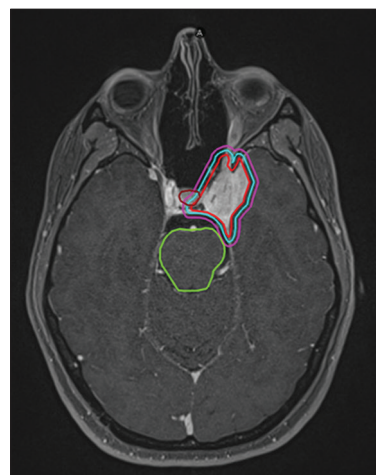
Pre-treatment magnetic resonance imaging (MRI). Colours only provide a visual representation of the cited area (pre-treatment masses).
